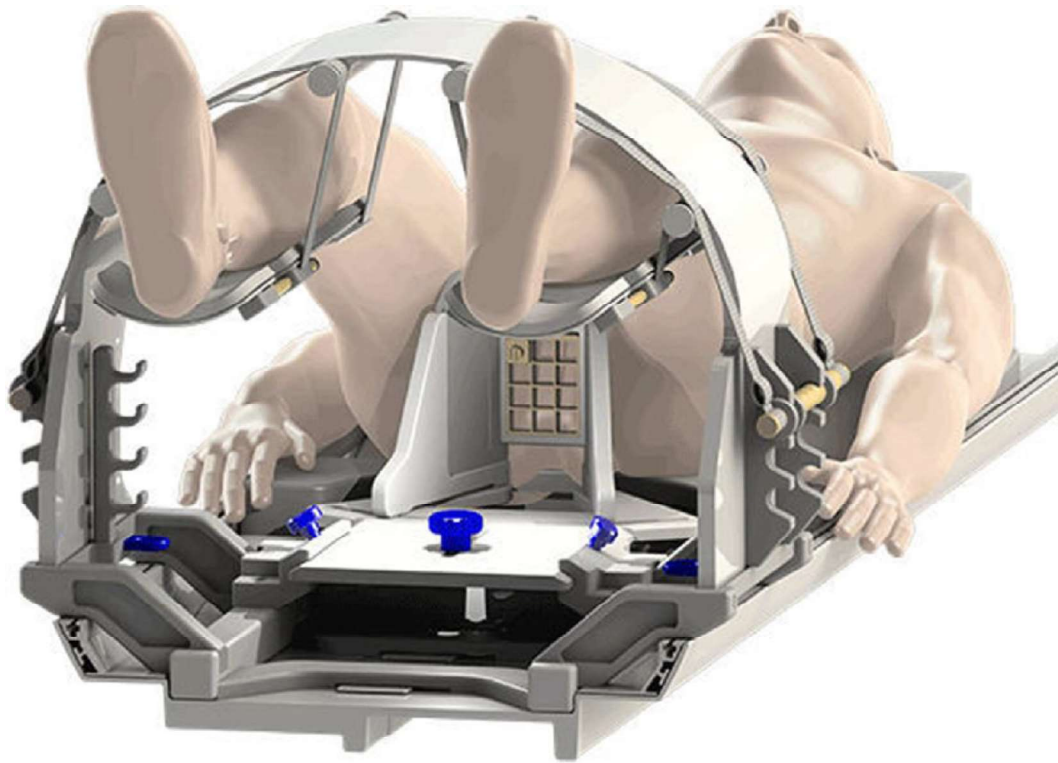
MRI safe stirrup device for transperineal biopsy or DaRT procedure interventions
